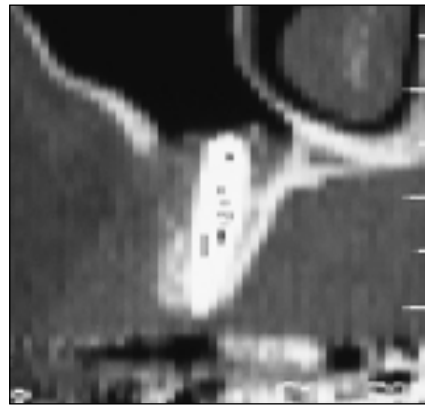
CT scan showing supporting bone around the implant in the augmented sinus.
